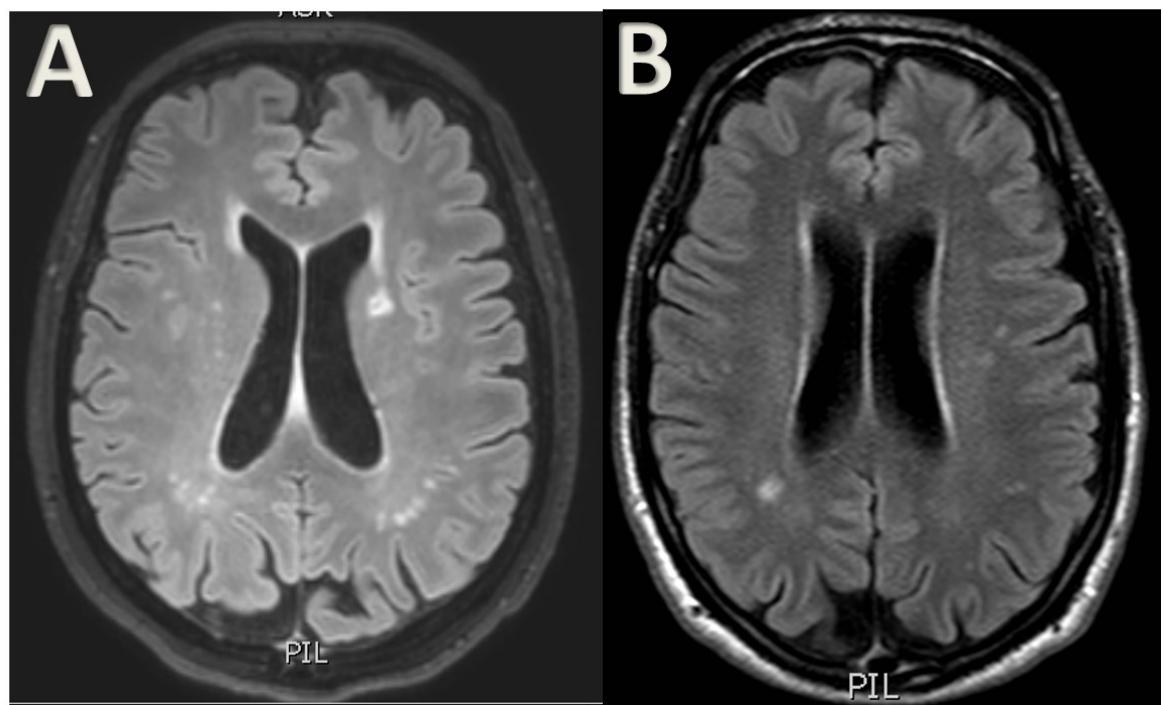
White matter changes in MRI Flair sequence: deep, subcortical and periventricular hyperintensities. 1A- Patient 2a, 32 years old and 1B- Patient 2b, 41 years old.
